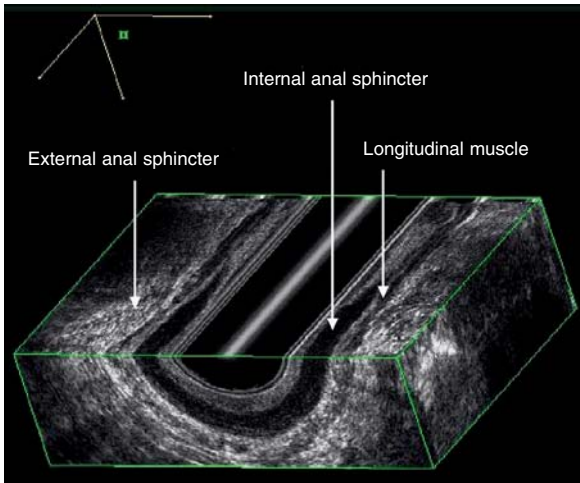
Normal ultrasound anatomy of the sphincter complex in three-dimensional image
